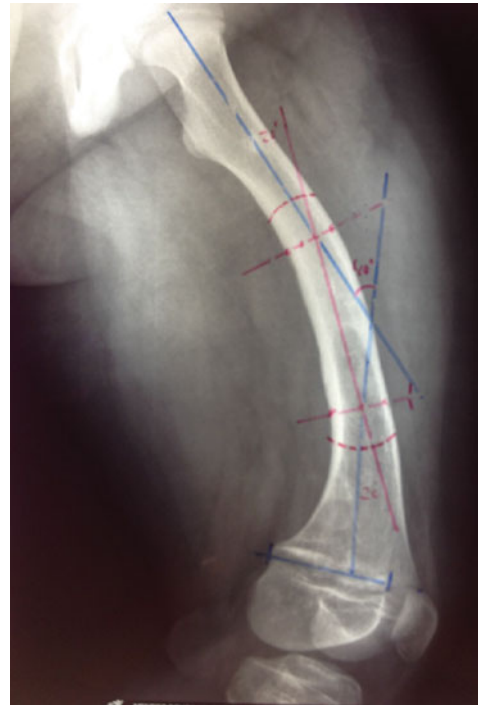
Preoperative planning of left femur, lateral X-ray showing multiapical deformity. The total deformity is 50° but resolves best to a proximal deformity of 20° and a distal deformity of 26°
